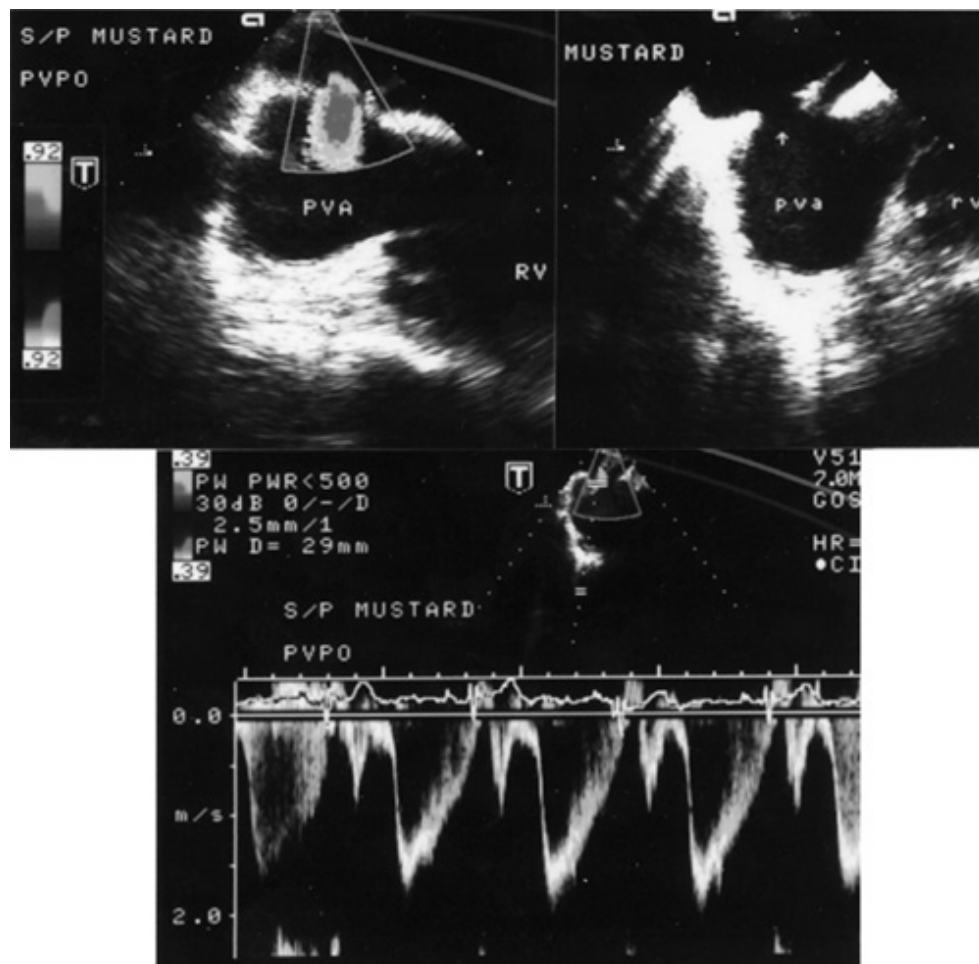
Transesophageal echocardiogram and Doppler evaluation after a Mustard operation for transposition of the great arteries. There is moderate pulmonary venous obstruction, indicated by the accelerated flow through the narrowing indicated by the arrow. PVA, pulmonary venous atrium; RV, right ventricle. (Courtesy of Dr. I. D. Sullivan, Great Ormond Street Hospital for Children, London.)
